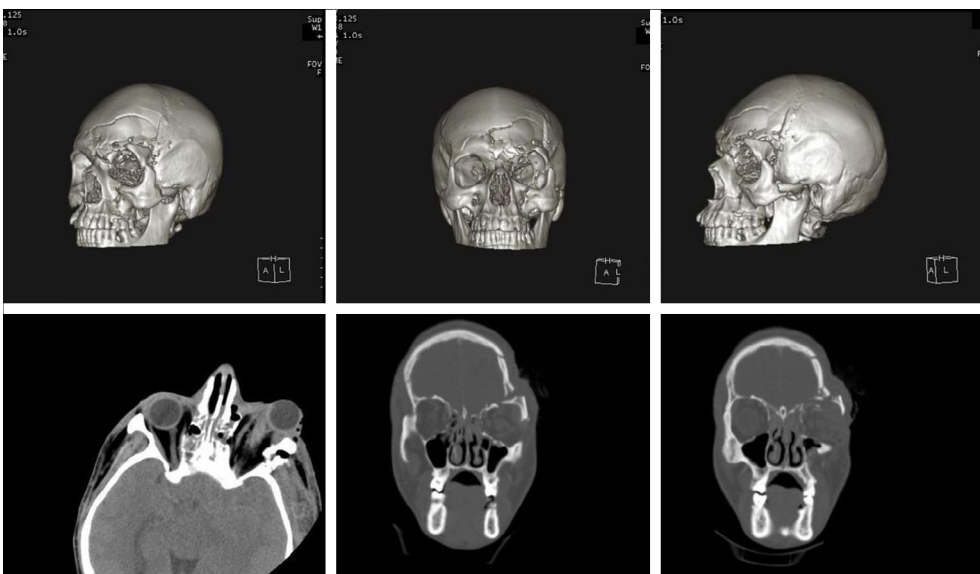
Computed tomography and 3D CT image of the fracture in the orbital walls.
